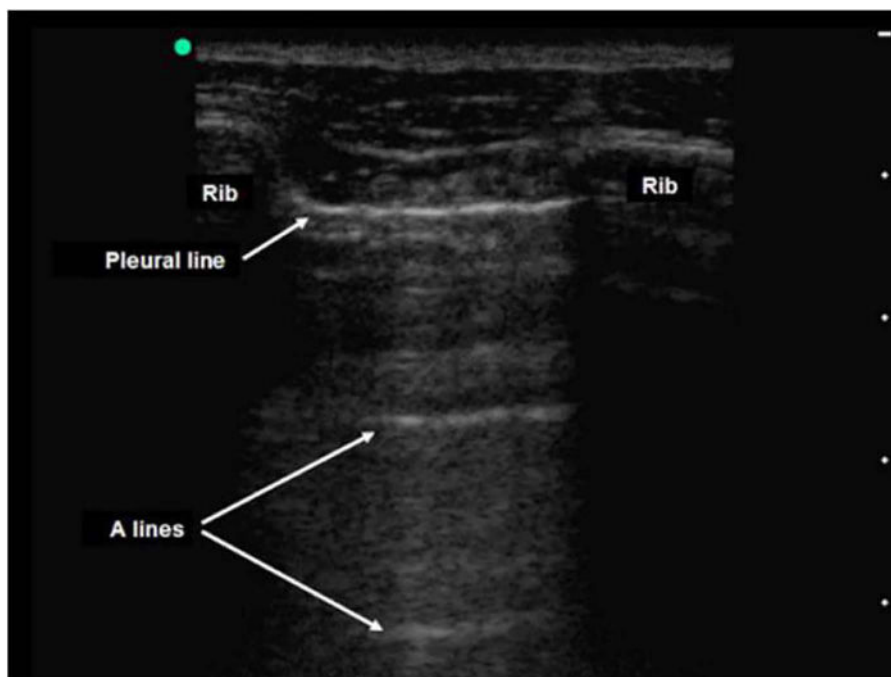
An ultrasound image of the thorax using a linear probe. The pleural line below ribs. Note the shadowing directly under the ribs as ultrasound beams do not penetrate bone. A lines: Horizontal bright lines at equidistant intervals below the pleural line. This is a normal finding in lung ultrasound (figure courtesy of Elaina Lin).
